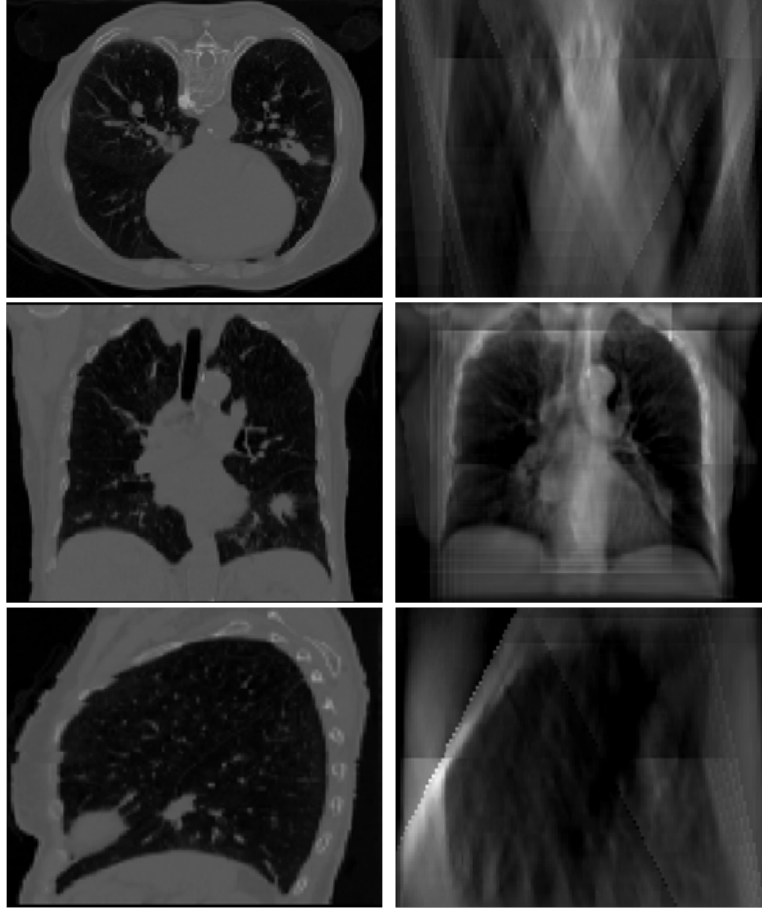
Nanotube Stationary Tomosynthesis (NST) image artifacts. Left: The axial, coronal and sagittal views of a diagnostic CT scan taken at the end of inspiration (EI) phase taken at the treatment planning time. Right: The axial, coronal and sagittal views of a NST image at EI phase, having interfering blurry patterns due to the limited angle reconstruction.
